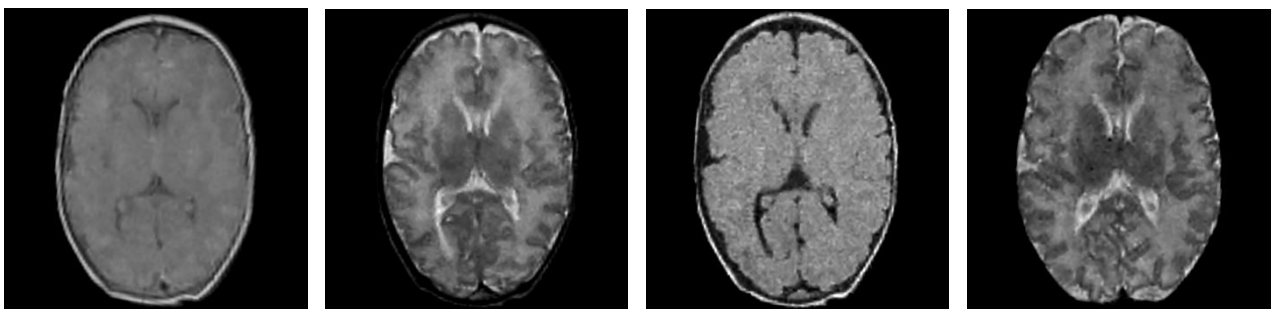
Image contrasts from left to right: TSE T1, TSE T2, TSE T2 FLAIR, TSE T2 STIR
